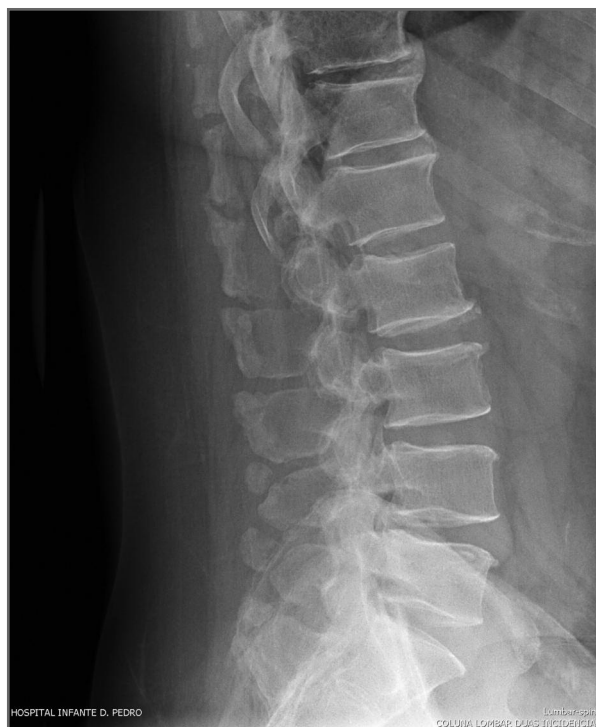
Lumbar spine radiography (lateral view)
